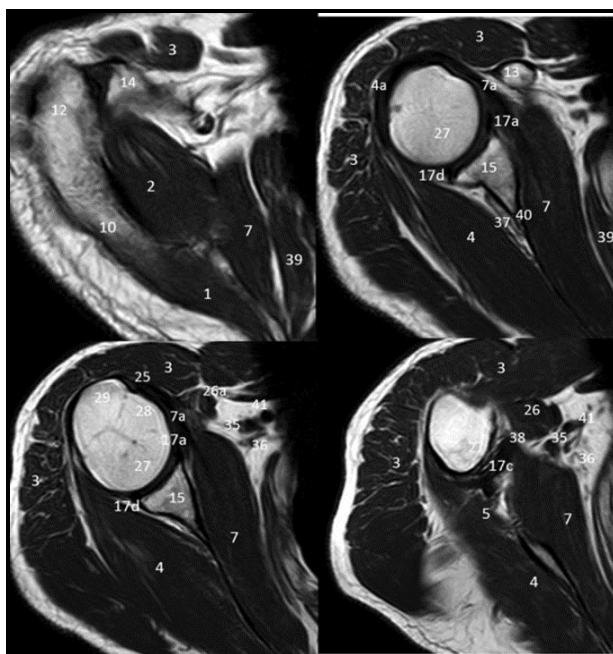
Shows MRI anatomy of the shoulder muscles.
